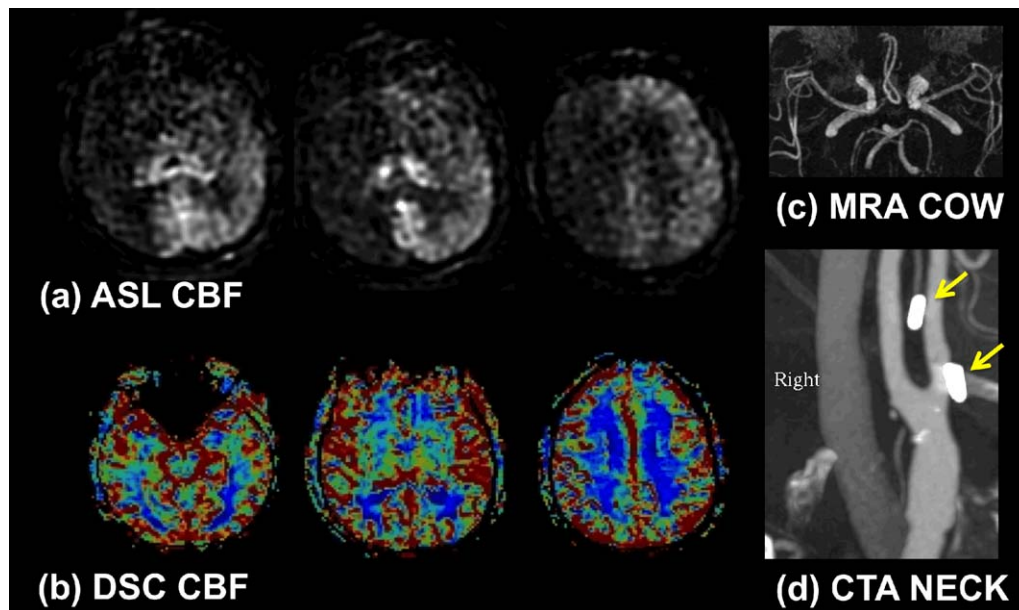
a: Example of poor PCASL labeling within the right anterior circulation due to poor labeling of the right internal carotid artery. Note the loss of ASL signal confined to this territory without compensatory collateral flow. b, c: In this case, confirmation was obtained with a (b) normal dynamic susceptibility contrast CBF map and (c) normal MR angiogram of the circle of Willis. d: CT angiogram demonstrates surgical clips in the region of the right internal carotid artery (arrows), which may have been responsible for the poor labeling due to susceptibility effects.
